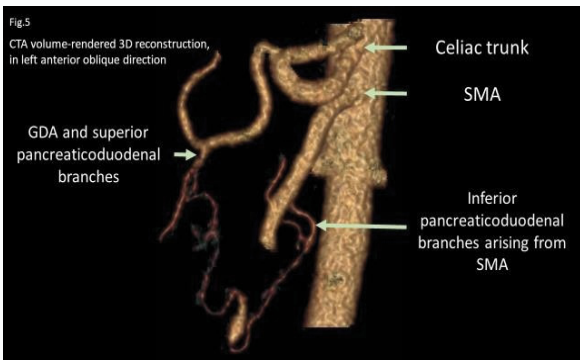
CTA volume-rendered 3D reconstruction, in left anterior oblique direction.
